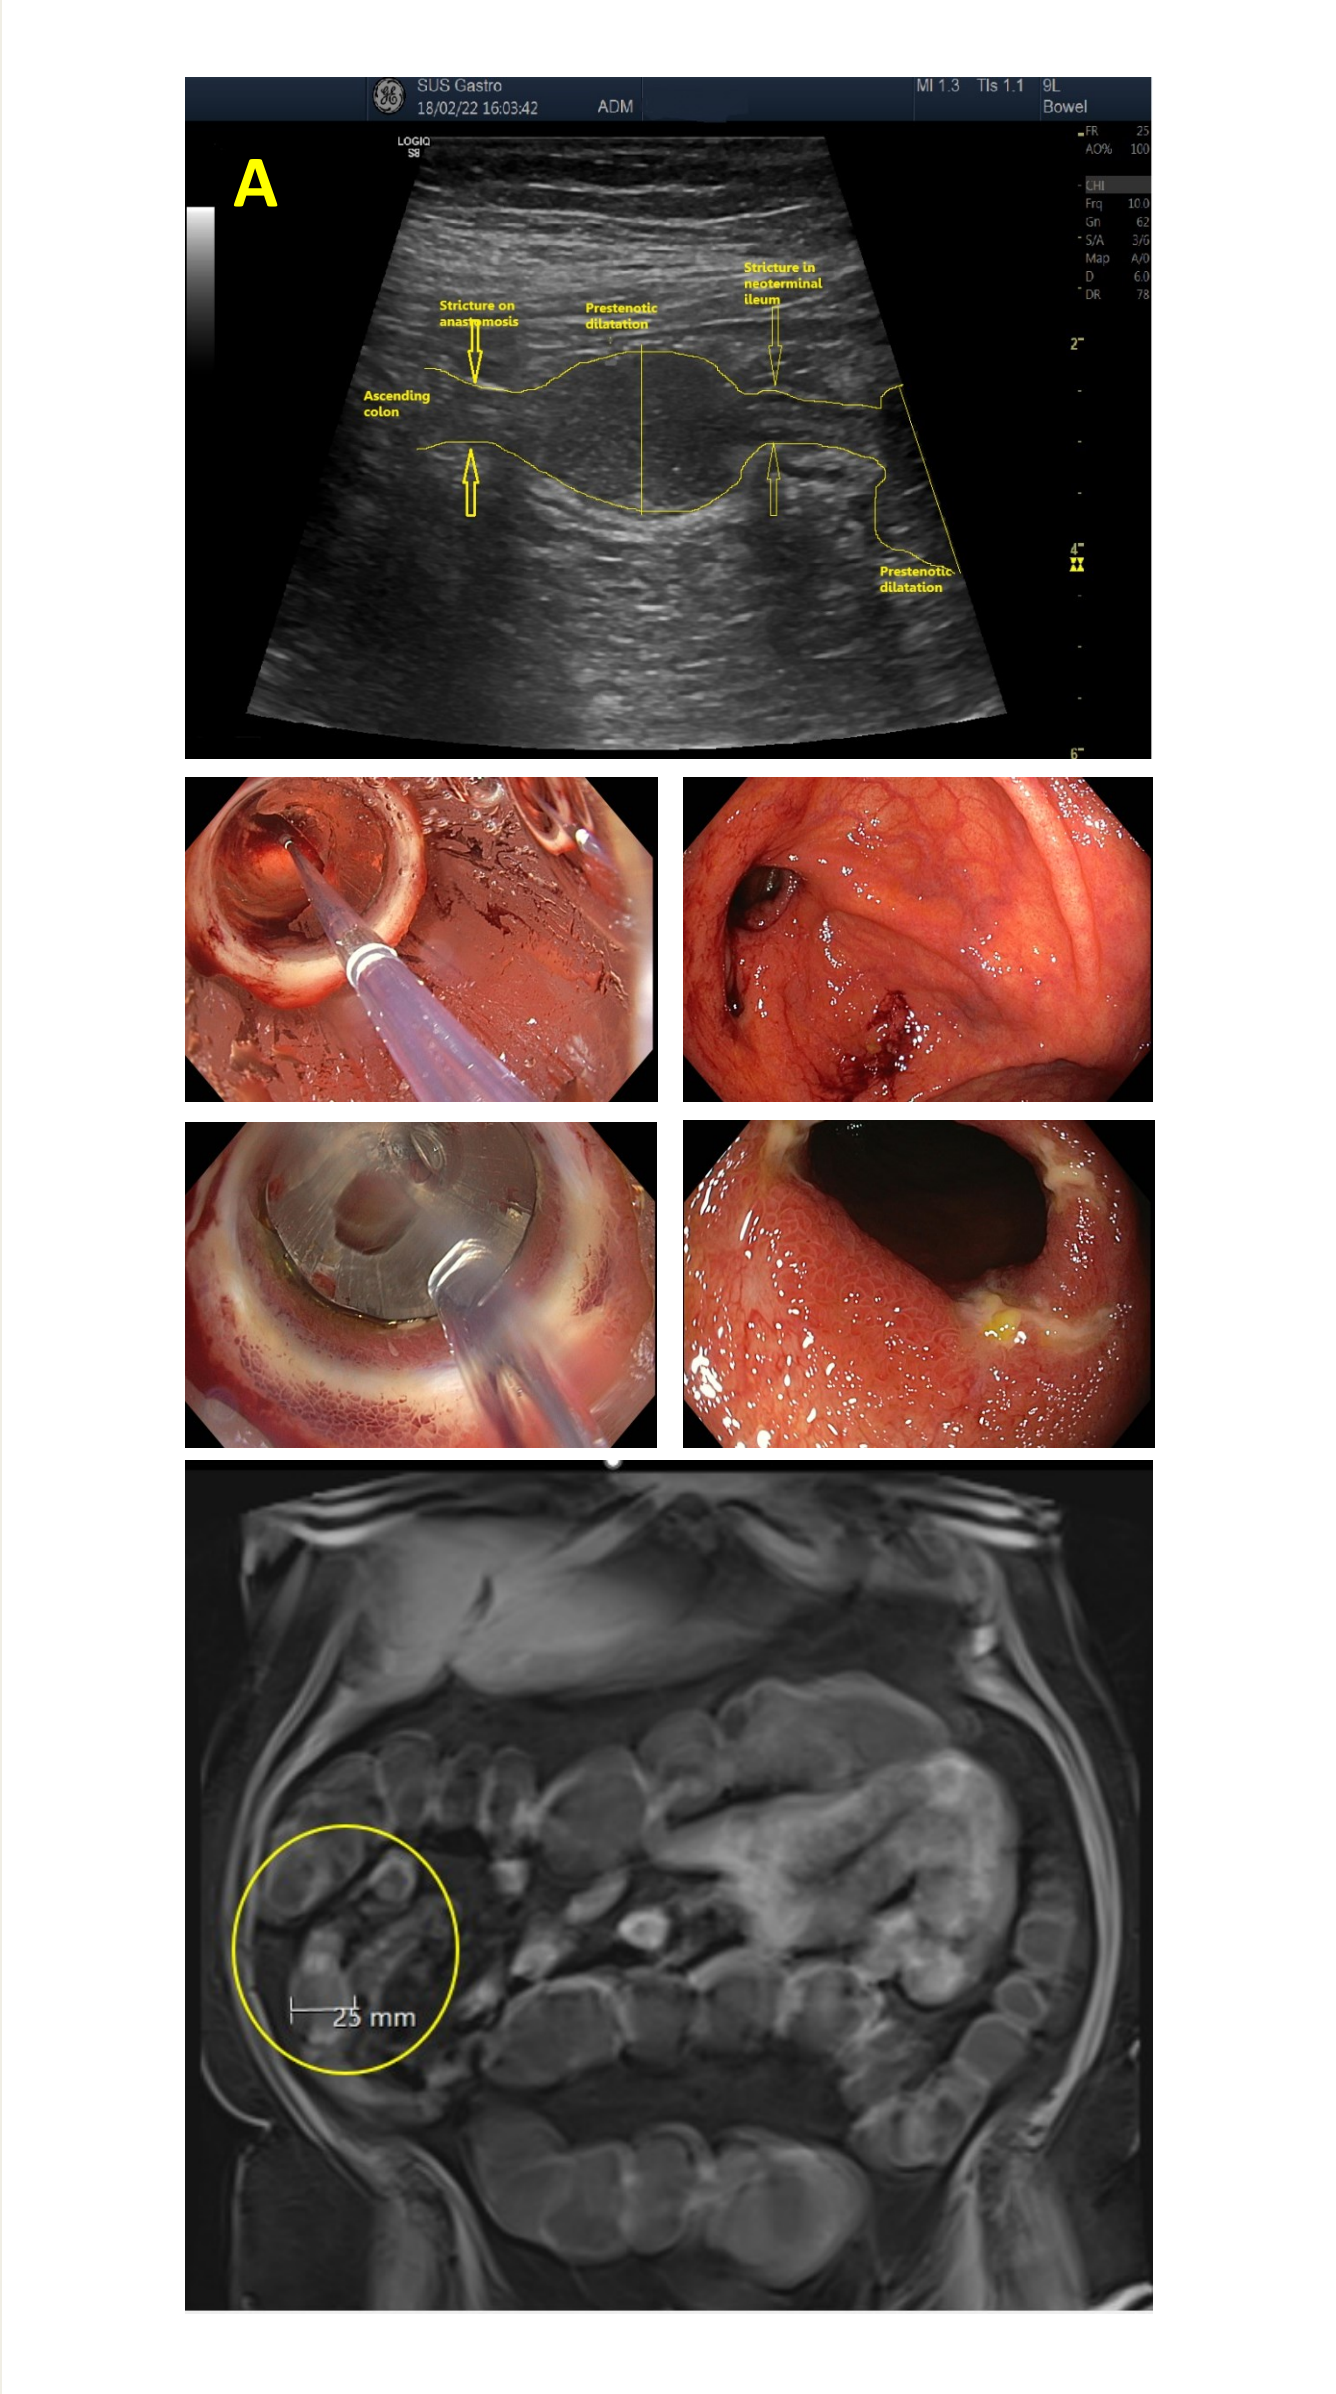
A. SICUS showing two short strictures with prestenotic dilatation. Endoscopy images show balloon dilatation of the stricture at the anastomosis and in the neoterminal ileum. The T1-weighted sequence of MRE image shows these two strictures within the yellow circle.
